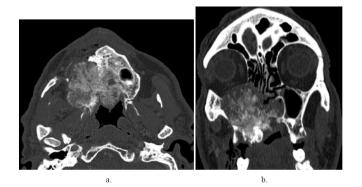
(case 15). 62-year-old male patient with osteosarcoma. (a) Axial and (b) coronal contrast-enhanced maxilla computed tomography examination showing a malignant mass lesion that causes destruction in bone structures, has dense calcific components, extends to the left along the hard palate in the right maxilla, completely fills the maxillary sinus, extends into the nasal cavity, and invades the nasal septum.
